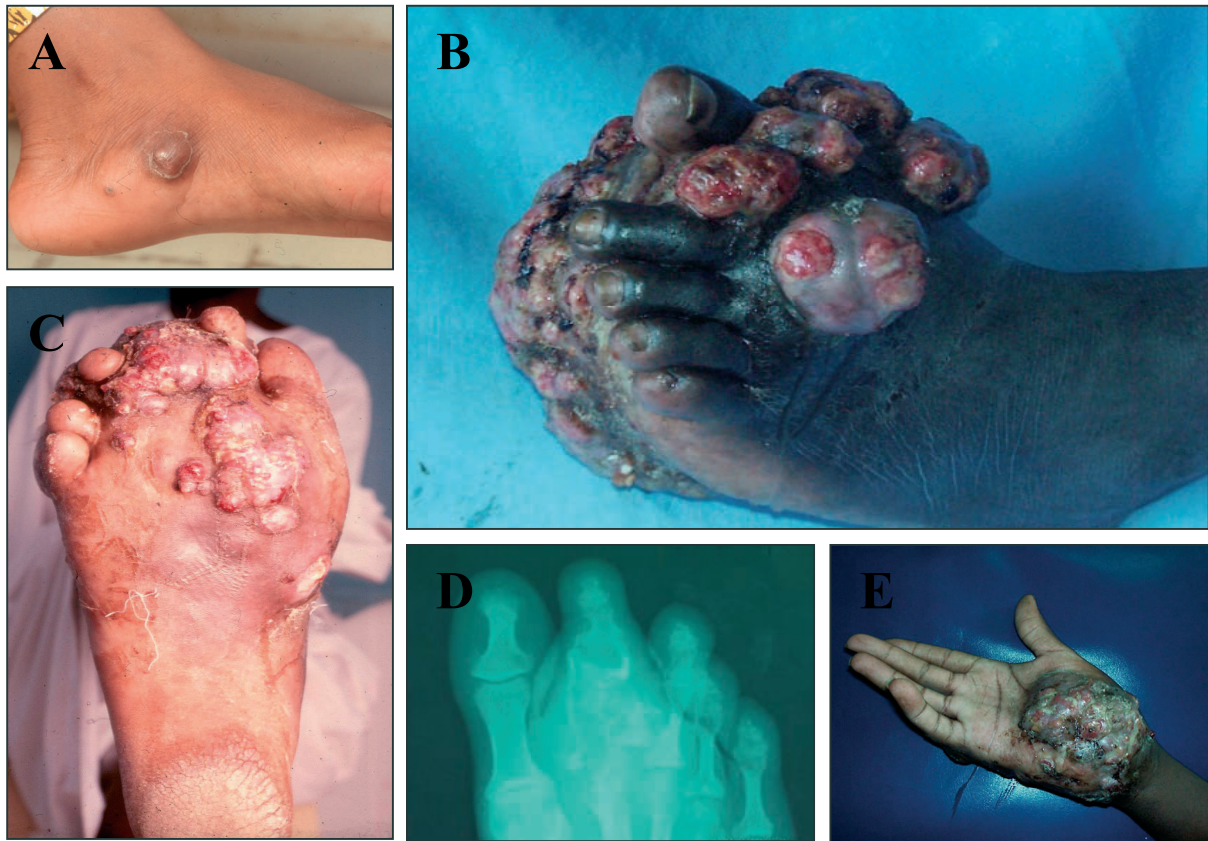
The clinical presentation of mycetoma. A: an early case of mycetoma of the foot; B and C: advanced cases of mycetoma of the foot; D: a X-ray showing bone destruction in mycetoma, E: advanced mycetoma of the hand, the second most common site for mycetoma.
